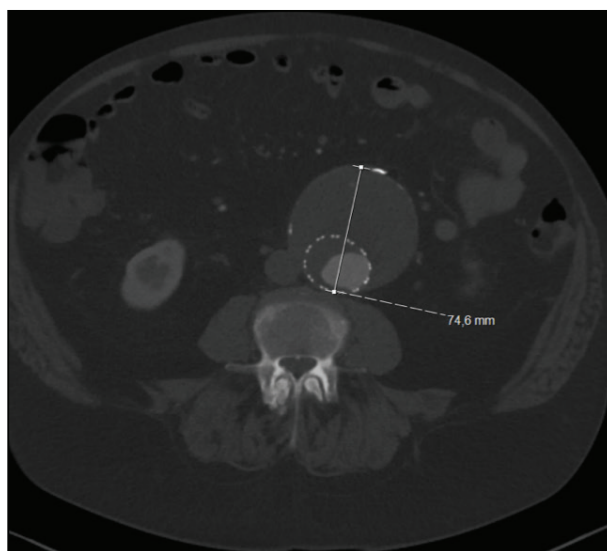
CTA from the Case 1 patient 5 years after treatment of the type II endoleak with a Concerto™ Helix detachable coil, now with decreased aneurysm diameter and no further endoleak. Individual results may vary.
